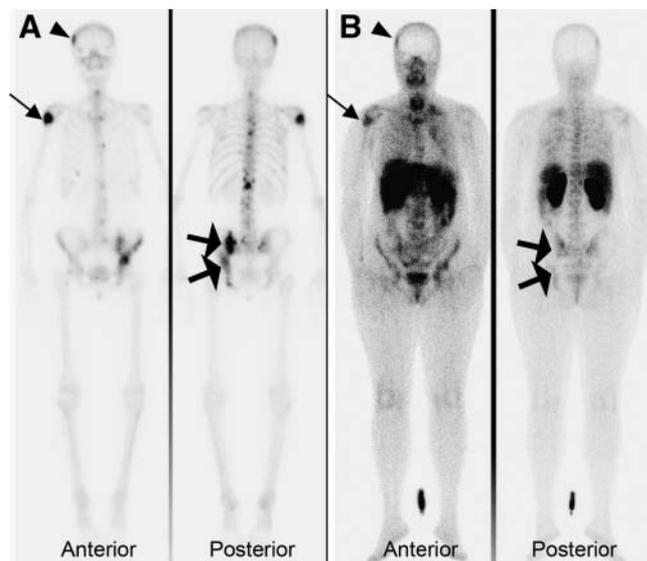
A 57-y-old woman (patient 15) presented with bone metastasis and achieved sustained disease stabilization on endocrine treatment. (A) ^{99m}Tc -Methylene diphosphonate bone scan shows multiple metastatic lesions, among others, of the skull (arrowhead), shoulder (thin arrow), and pelvic (thick arrow) region. (B) ^{99m}Tc -Depreotide scintigraphy, assessed before initiation of tamoxifen, shows uptake in the respective pathologic lesions.
